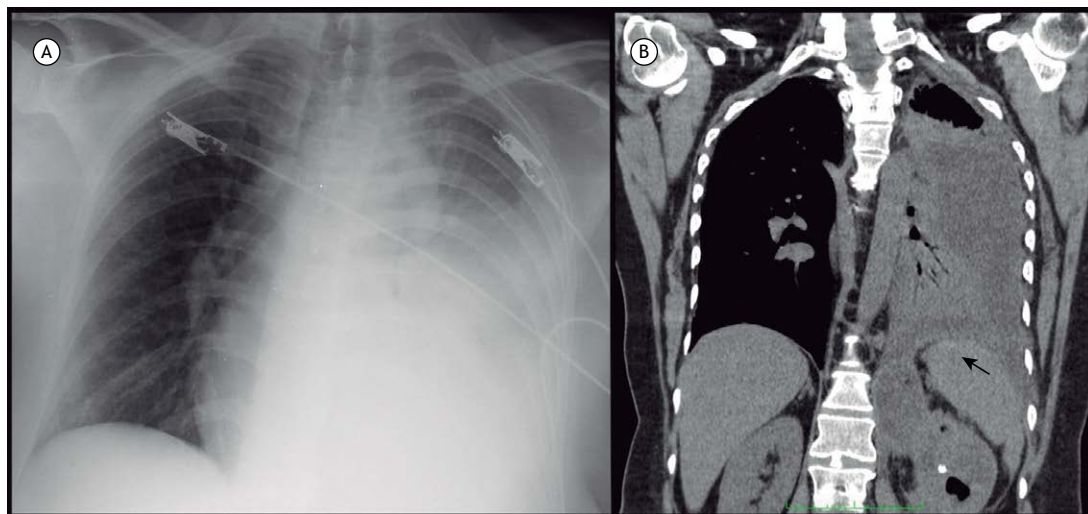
In A, an X-ray of the chest showing extensive left pleural effusion. In B, coronal reconstruction from a CT showing the left kidney with a calcified calculus and hypoattenuated areas, one of which draining to the perirenal space and causing left pleural effusion (black arrow).
